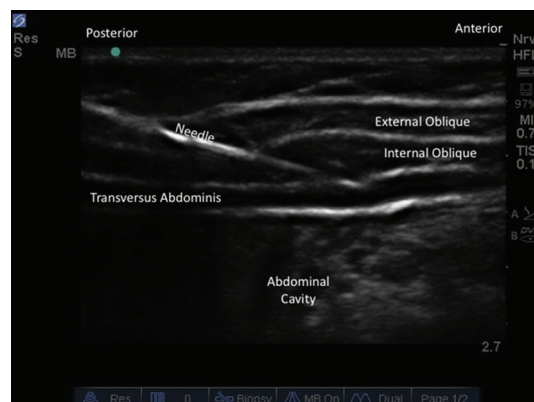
Transversus abdominis plane block as seen via ultrasound. Probe-positioned transverse over the lateral wall of the abdominal wall, midway between the subcostal margin and iliac crest.
